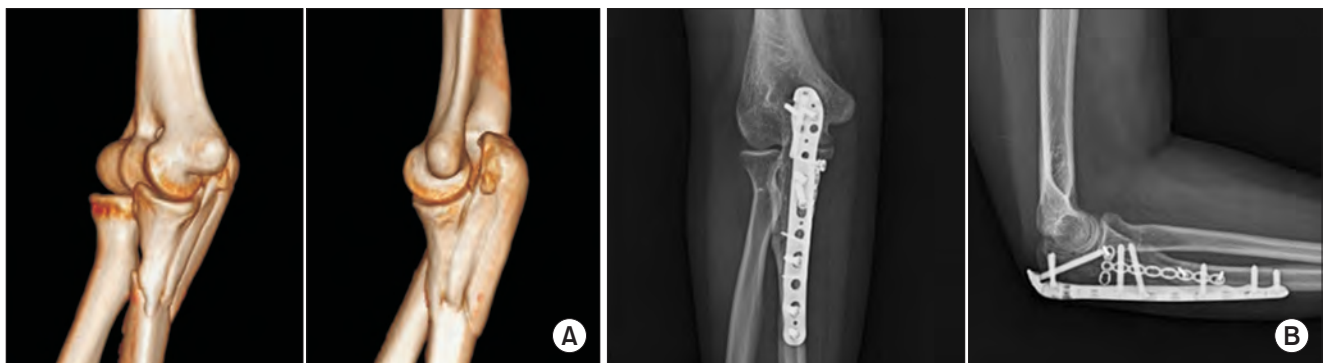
A 25-year-old woman classified as having a type 2 trans-ulnar basal coronoid fracture-dislocation. (A) Three-dimensional computed tomography reconstruction of the type 2 trans-ulnar basal coronoid fracture-dislocation. (B) Postoperative anteroposterior and lateral radiographs at the final follow-up.
